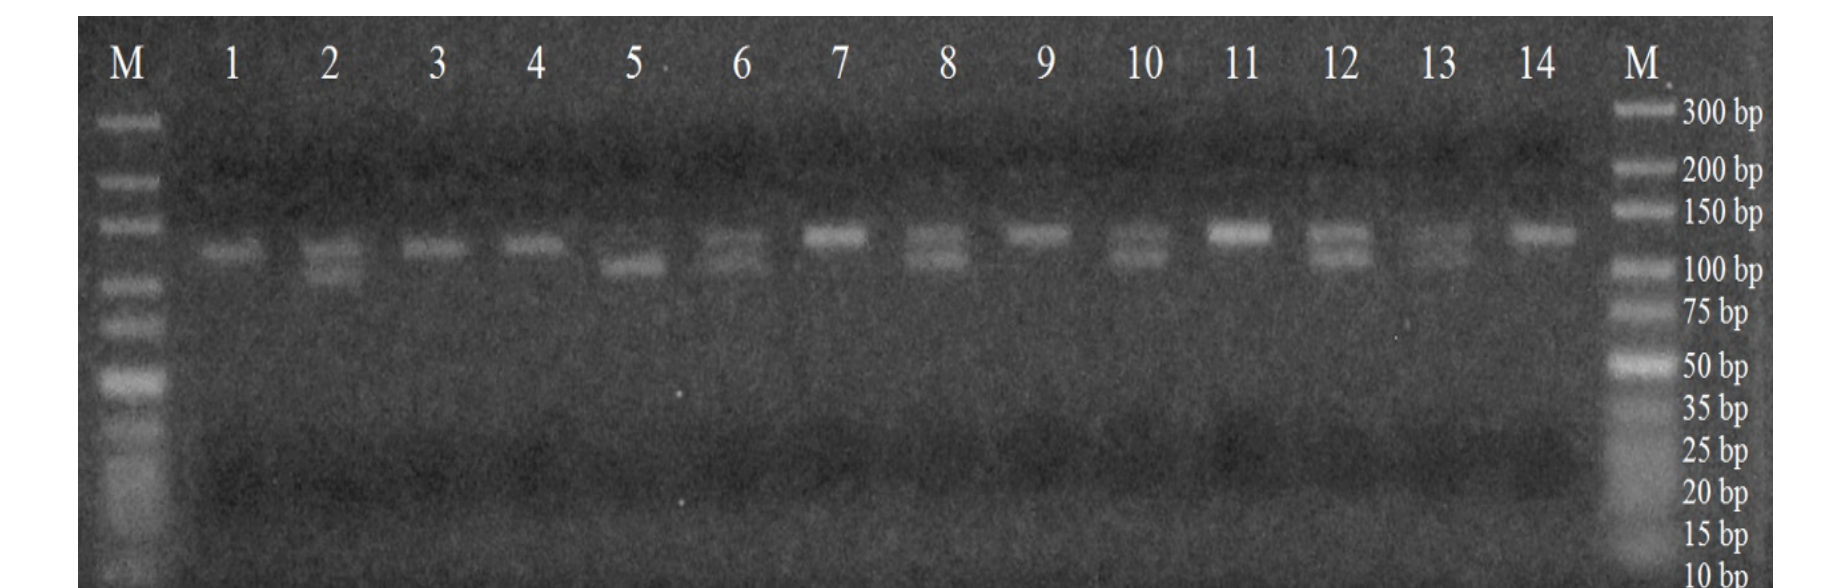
Agarose gel electrophoresis of RFLP products for MMP2 -1306C>T (rs243865) polymorphism analysis. Lane M - DNA molecular marker GeneRuler Ultra Low Range DNA Ladder (Thermo Fisher Scientific Baltics, Lithuania); Lanes 1, 3, 4, 7, 9, 11 and 14: CC genotype; Lanes 2, 6, 8, 10, 12 and 13: CT genotype; Lane 5: TT genotype.
